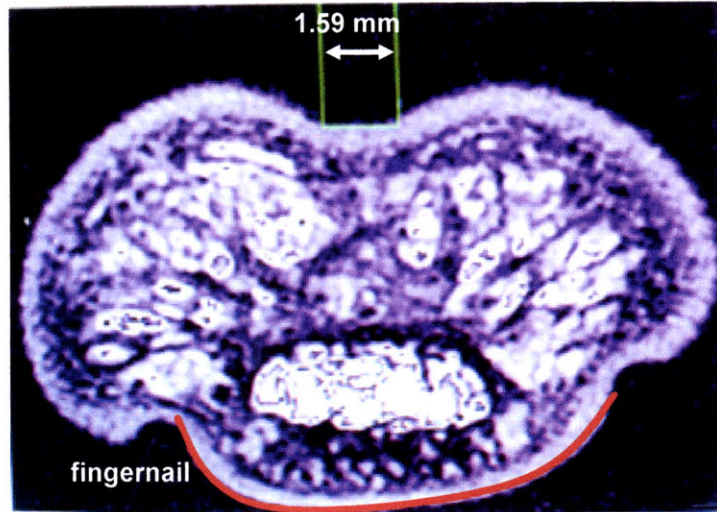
MRI image of a deformed fingerpad while loaded with a 1mm prescribed surface displacement [67].
